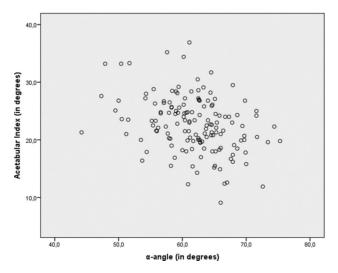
Correlation between acetabular index in radiographs and α -angle in ultrasounds.
